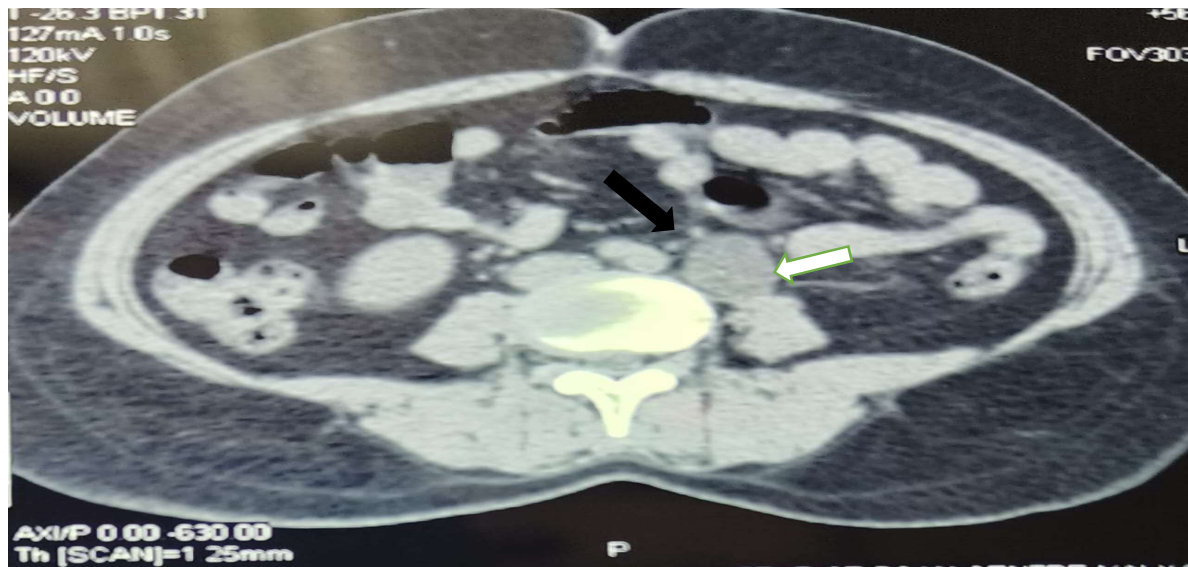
Axial section of CT KUB showing Left sided dilated ectopic ureter and left normal ureter. (Black Arrow-Left ectopic ureter and white arrow-Left ectopic ureter)
